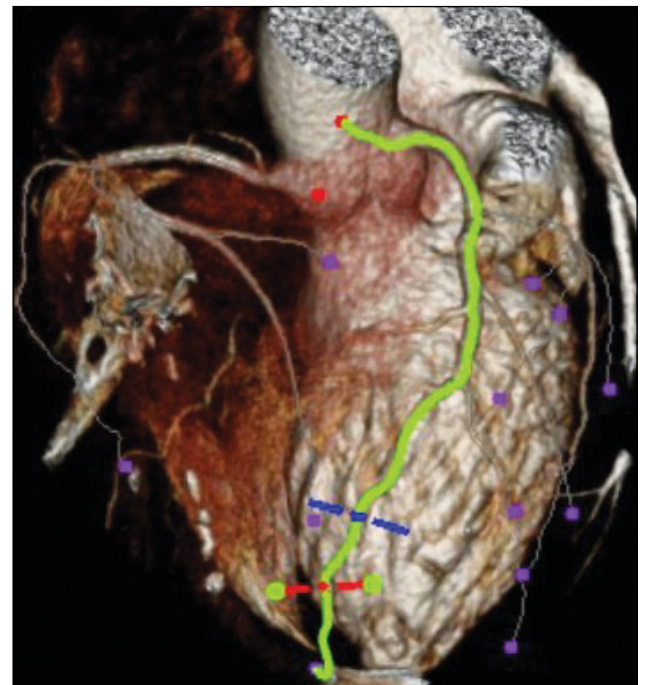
Cardiac CTA showing three-dimensional volume reconstruction, with LAD coronary artery outlined.
